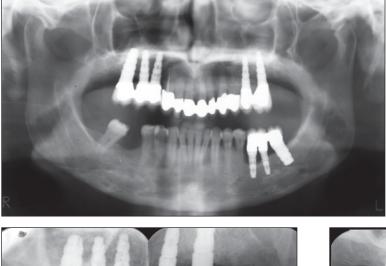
Postoperative intraoral radiographs (a) 1 and (b) 5 years postloading.
